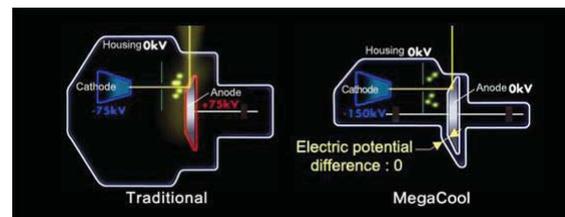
Traditional x-ray tube vs Toshiba's MegaCool. [8]
